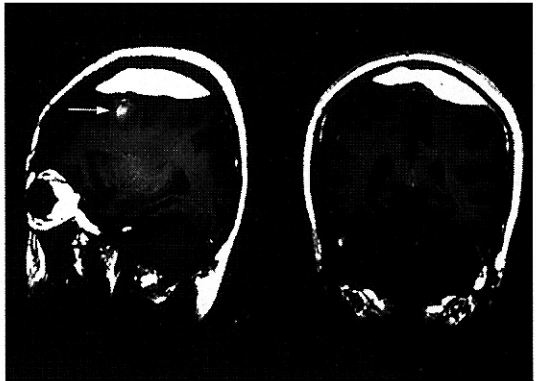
Preoperative MRI, T1-weighted image. Subacute stage of the vertex epidural hematoma and frontal hemorrhagic contusion(arrow) are clearly defined.
